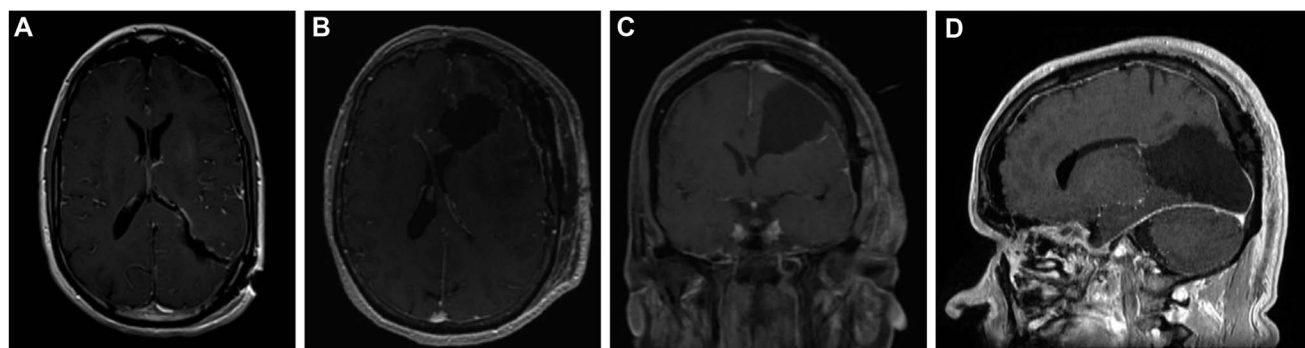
Magnetic resonance images demonstrating ventricular entry, A-D.
